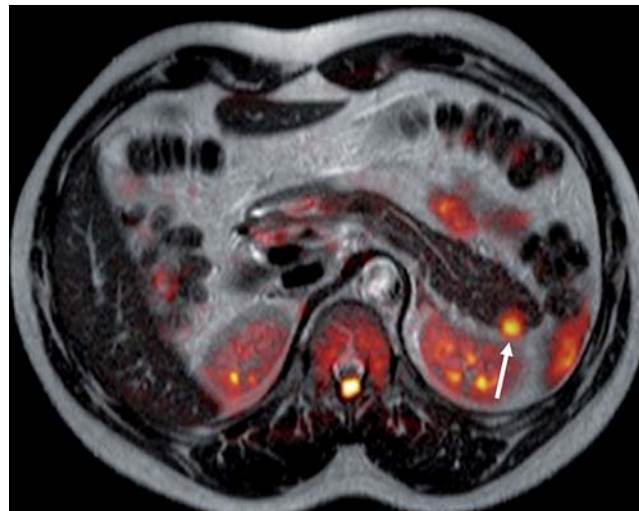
Axial coregistration of turbo spin echo (TSE) T2-weighted and diffusion-weighted sections shows a well-defined and very bright nodule in the tail of the pancreas (arrow).
